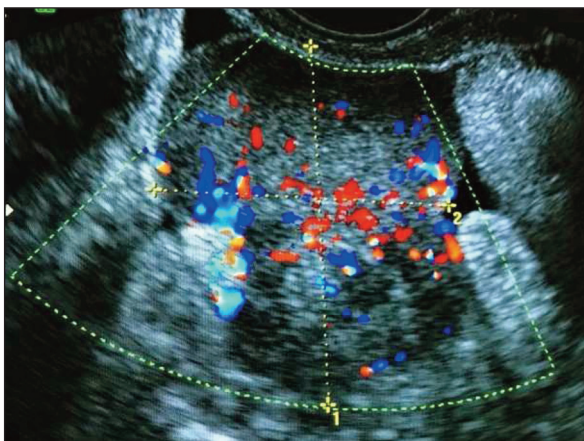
Ultrasound image of the highly vascularized peritoneal nodules.
